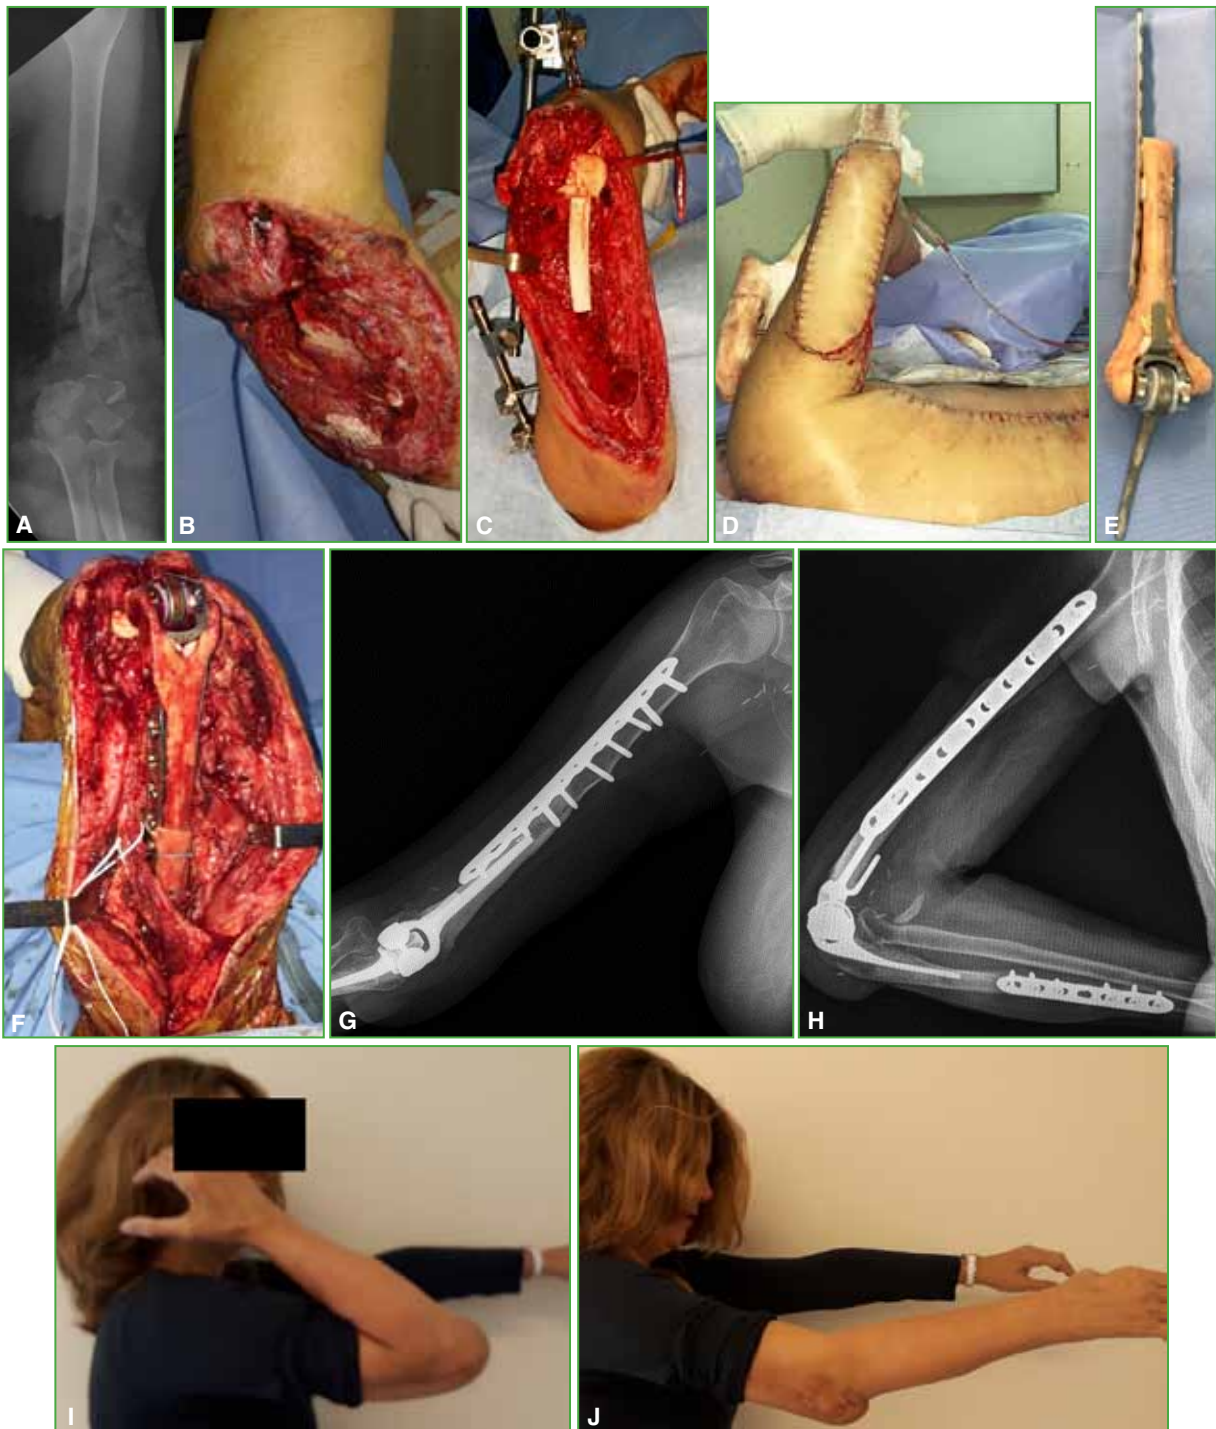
A. Humerus radiograph of a 51-year-old woman (case 9) with sequela of an exposed infected fracture of one month of evolution. The great loss of bone stock is observed. B. Posterior soft tissue loss (including the extensor apparatus). C. Cement spacer with antibiotic and external tutor. D. Latissimus dorsi flap. E. Preparation of the distal humerus alloprosthesis. F. Alloprosthesis placed with good compression in the osteotomy. G and H. Radiograph 2 years after surgery. I and J. Final mobility.
